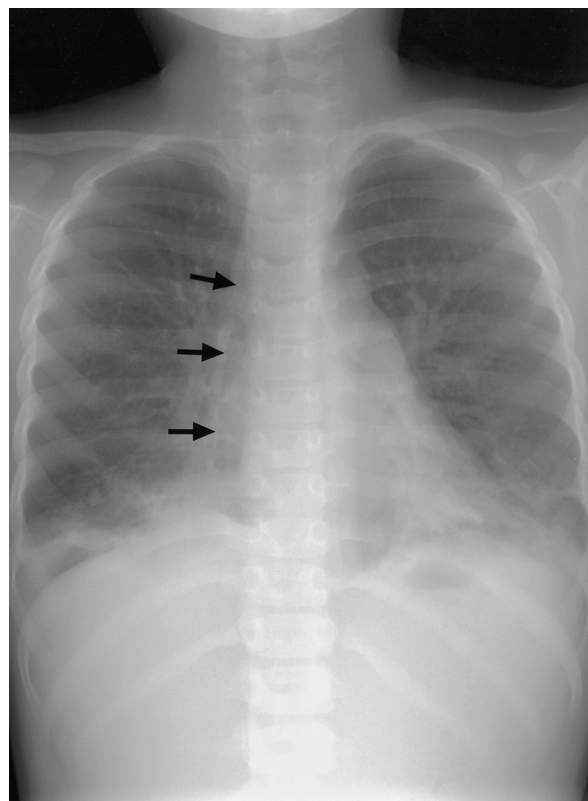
Plain chest radiograph shows pneumonia in both basal lungs and elongated air density (arrows) along the right mediastinal border due to esophageal dilatation.
